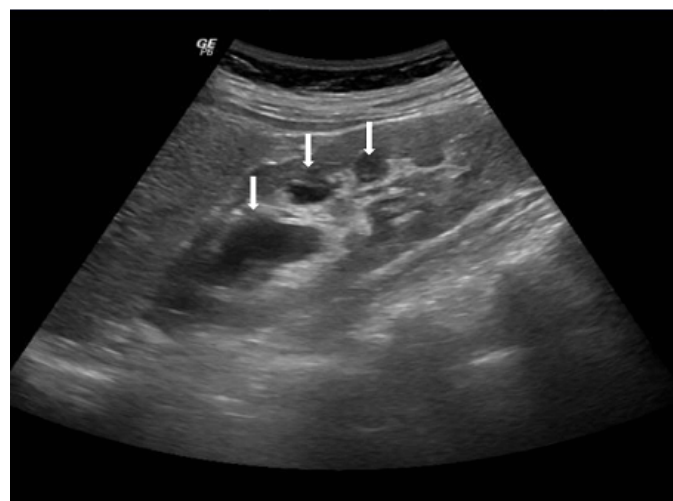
Ultrasound showing increased right kidney, with pyelocaliceal dilation (arrows).
